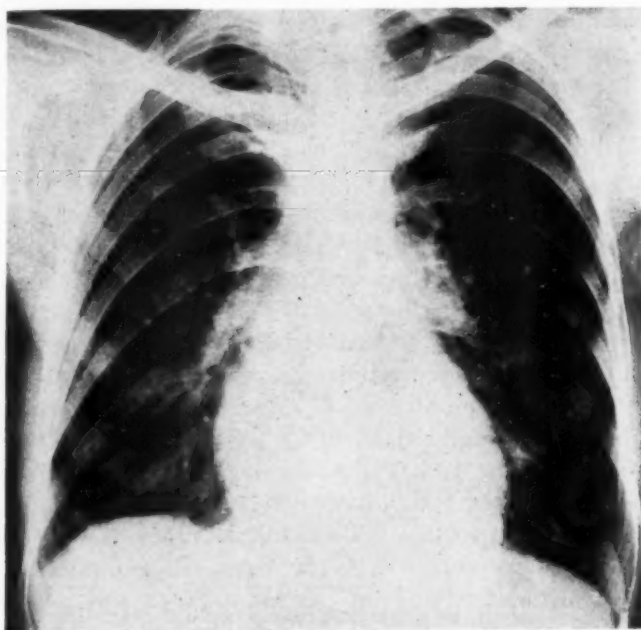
(Case 1).—The roentgenogram of the chest shows moderate, generalized enlargement of the heart with exaggeration of bronchovascular markings bilaterally.
